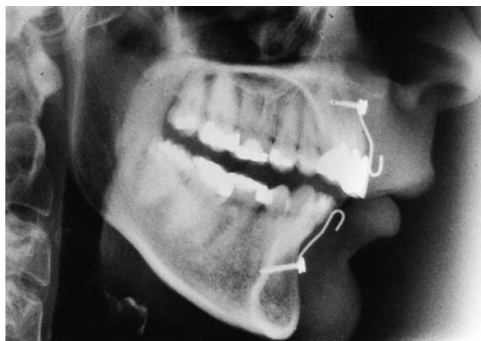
X-ray lateral view with hypomochlion in place
